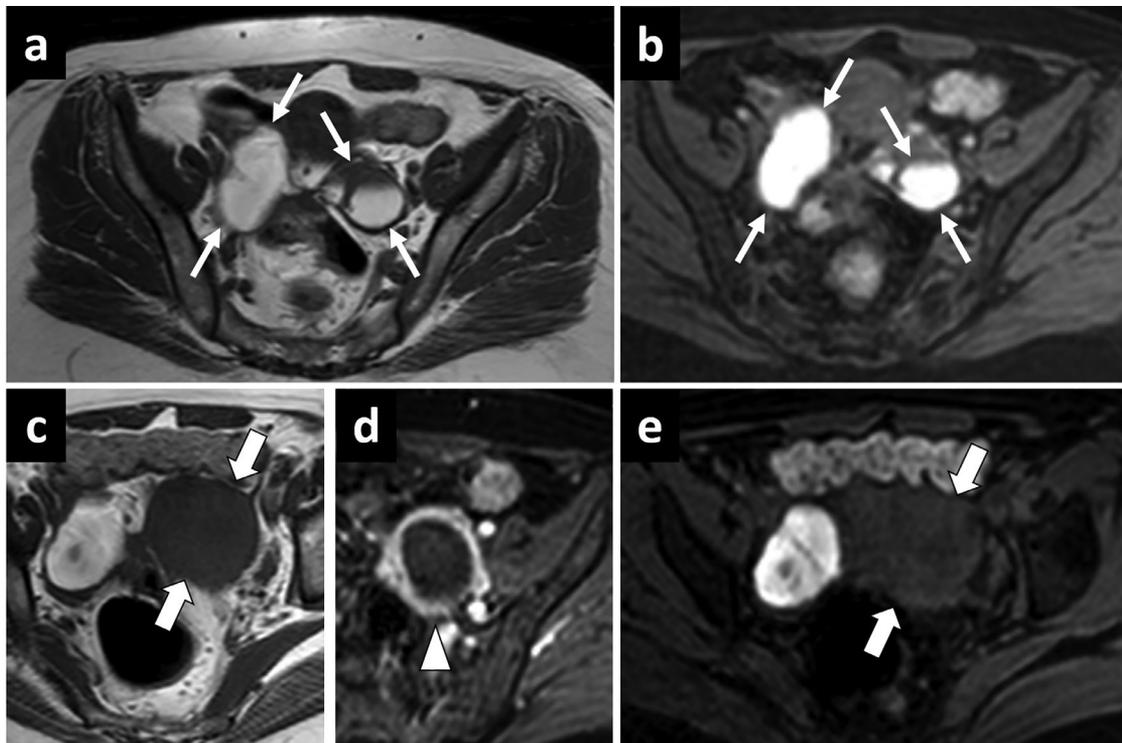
Left-sided tubo-ovarian abscess. (A and B) Axial plane T1W (A) and T1W fat-suppressed (B) baseline pelvic MR images 6 months before the patient’s clinical presentation show «kissing ovaries» and bilateral T1 hyperintense endometriomas (small white arrows, A and B). (C–E) Axial plane T1W (C), T1W fat-suppressed postcontrast (D), and T1W precontrast (E) MR images at the time of clinical presentation demonstrate complete reversal of the previous T1 signal hyperintensity of the left adnexal lesion with a notable size increase (large white arrows, C and E). Note was also made of enhancing thick walls (arrowhead, D) and septation of this lesion (not shown). Imaging findings were found to be consistent with tubo-ovarian abscess secondary to infected endometrioma.
